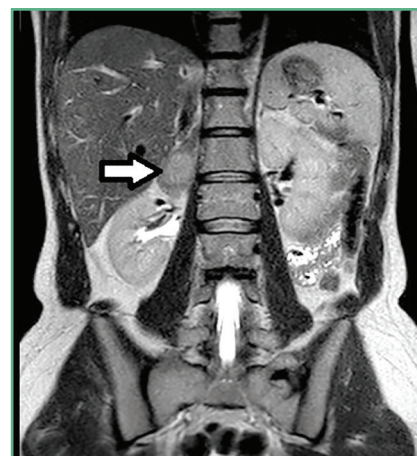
An MRI of a benign right-sided adrenal mass
